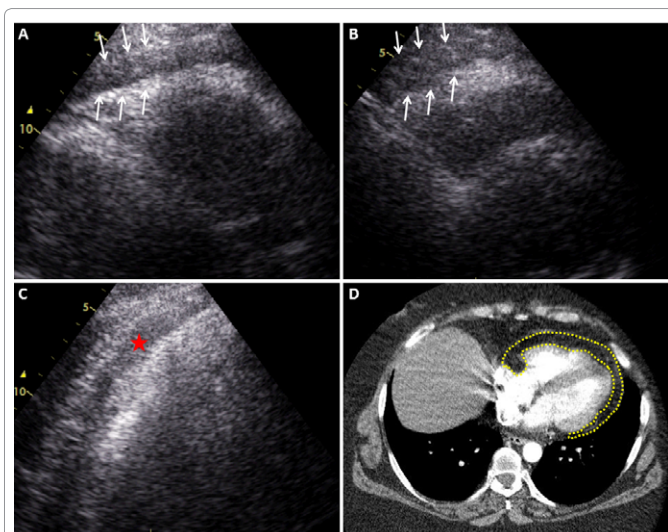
A-B: Parasternal long and short axis views showing pericardial echo-free zone (arrows). The image quality is not sufficient to differentiate pericardial effusion from epicardial fat. C: Apical four chamber view showing pericardial echo-free zone (asterisk). D: Epicardial fat recognized from pericardial effusion by chest contrast-enhanced computed tomography (dotted line).
